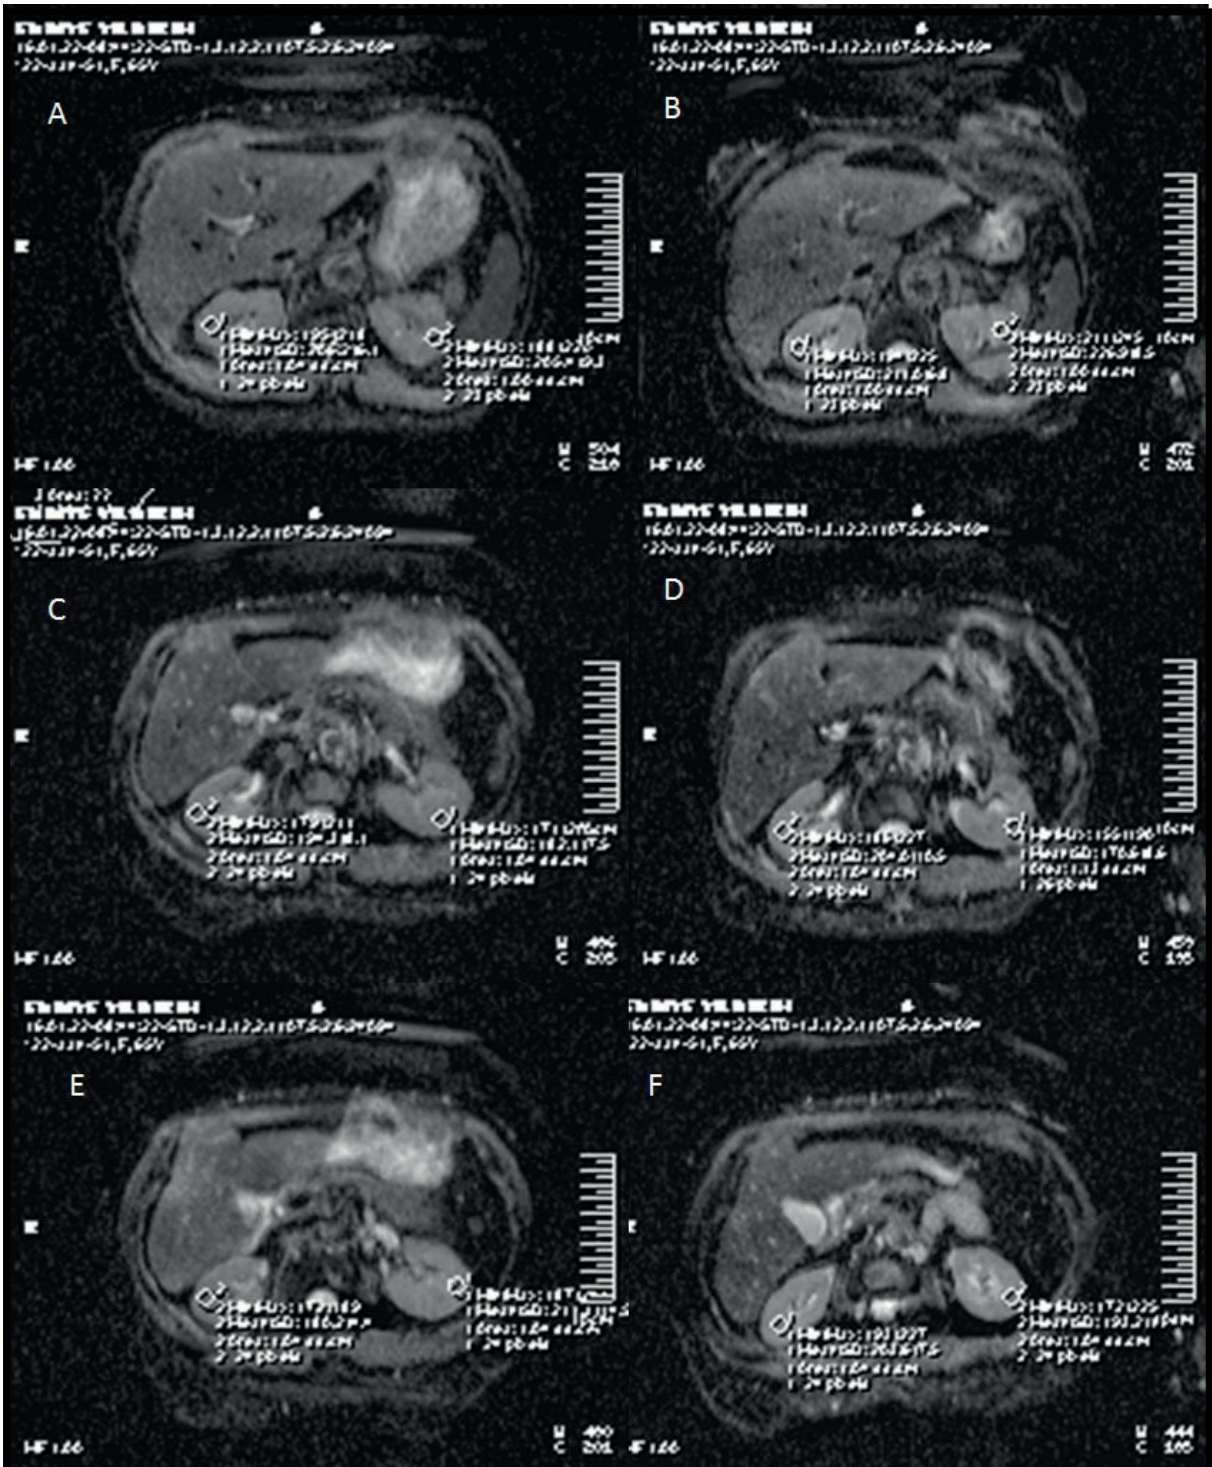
In a 58-year-old male patient with GFR>60, ADC measurements are observed on the upper-middle-lower pole and both kidneys on the ADC images before the MRI examination.
